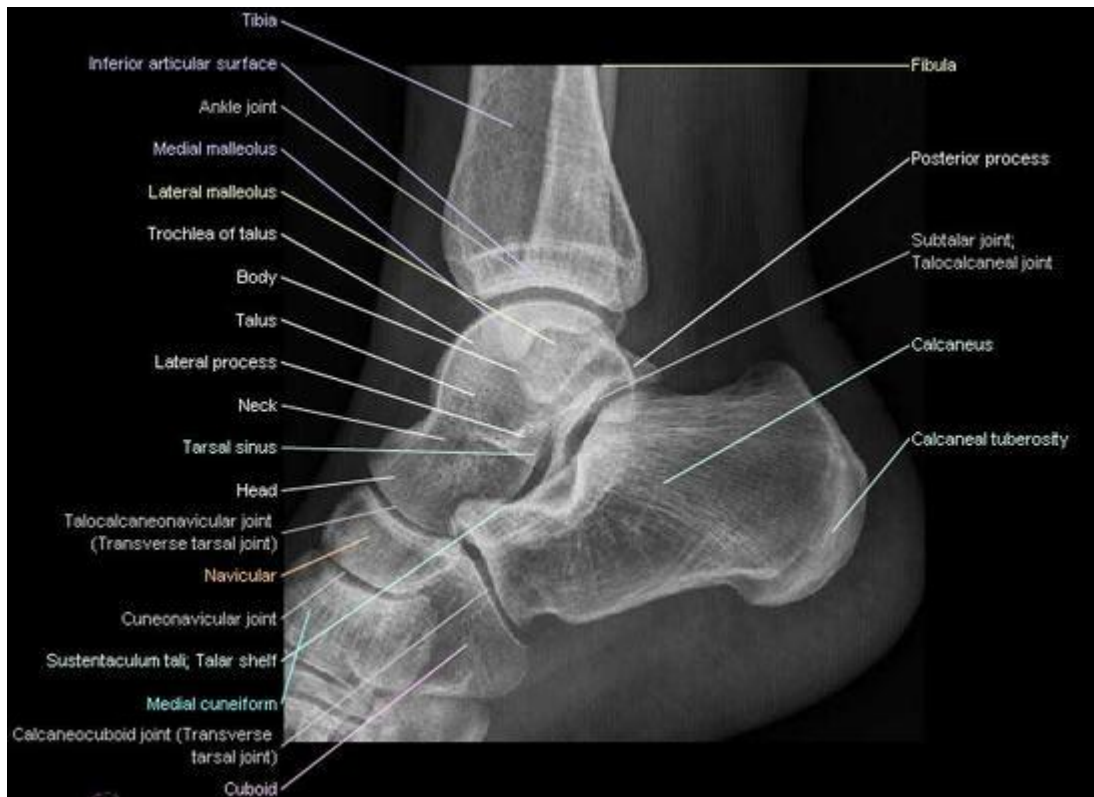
Radiographic medial view of the ankle joint. (www.e-radiography.net, 2012)
